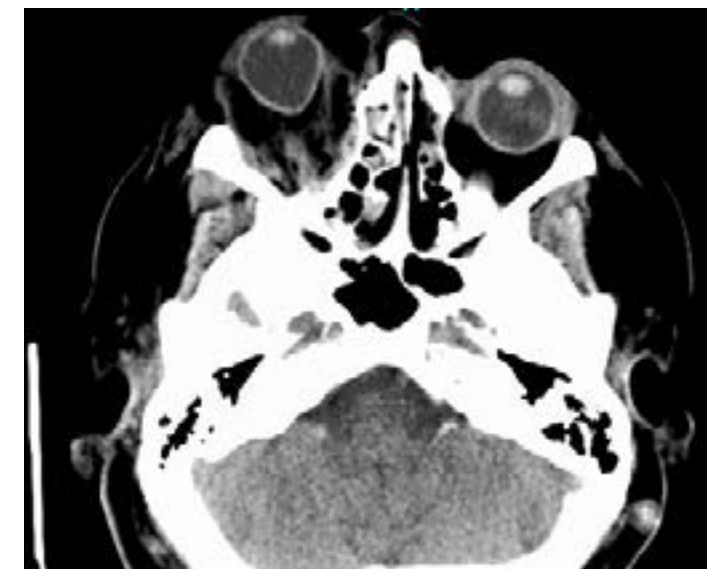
CT maxillofacial: proptosis of the right eye, with teardrop sign (referring to the shape of the eyeball) as well as retro-orbital stranding consistent with blood in the orbital compartment
